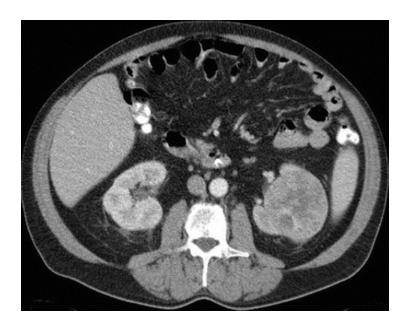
Contrast-enhanced CT demonstrates a heterogenous left interpolar renal cell carcinoma
